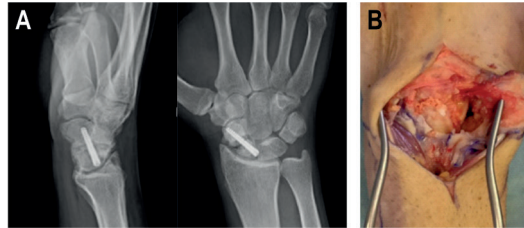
A) Initial radiographic, scaphoid non-union advanced collapse (SNAC) wrist; B) Intraoperative picture of arthrodesis (Ghargozloo D, 2017)
